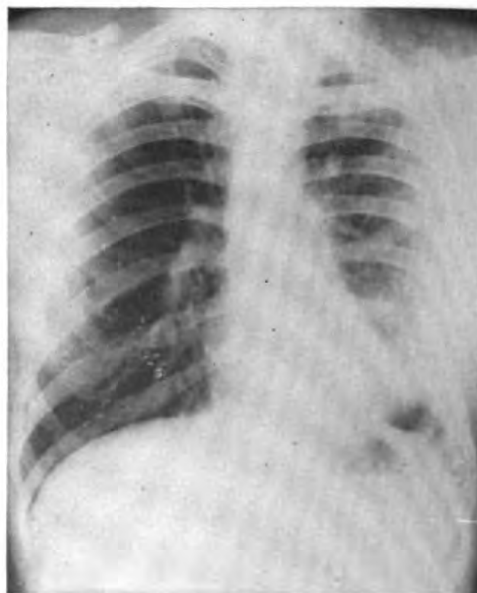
Case 4. Roentgenogram taken 3 months after thoracotomy with drainage. There is considerable residual pleural thickening on the left. The heart is shifted to the left, the diaphragm is elevated, and the costophrenic angle is obliterated.
